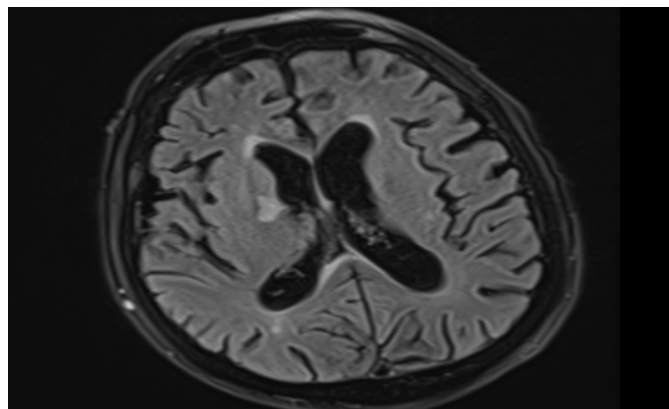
Cranial magnetic resonance imaging (MRI)
